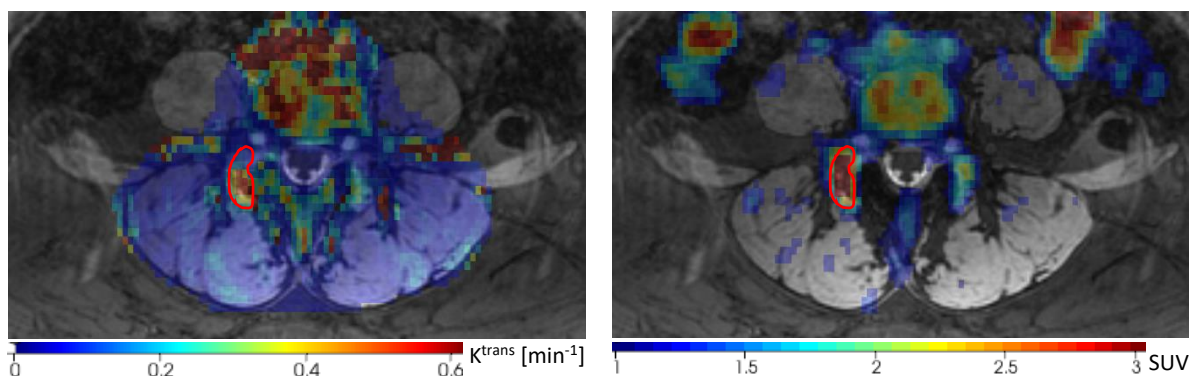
Example lesion ROI (red contour) in the right perifacet region at level L4/L5 showing focally increased K^{trans} (left) versus diffusely increased SUV (right). Parameter maps are shown as overlay images on the DESS scan. ROI: region of interest; SUV: standardized uptake value; DESS: double-echo steady-state
